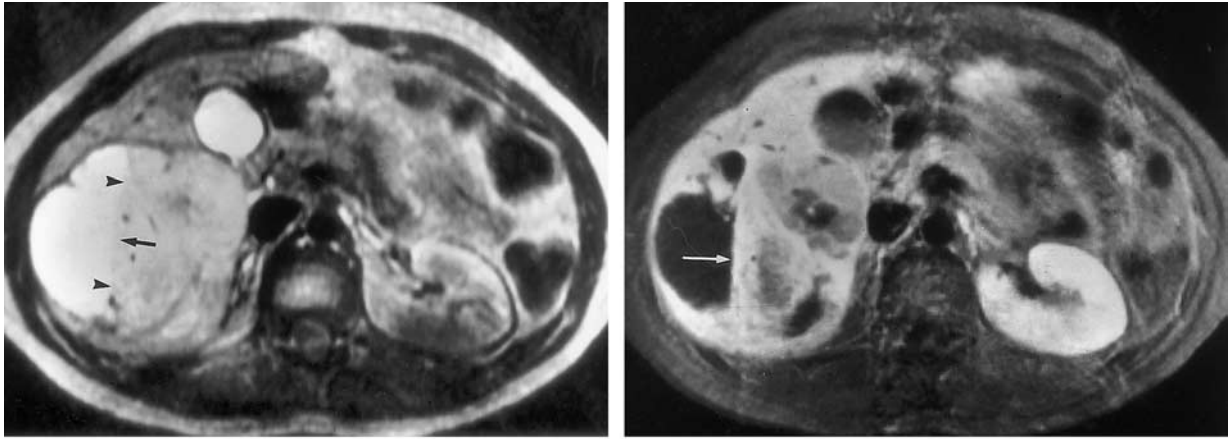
Undifferentiated embryonal sarcoma in a 36-year-old woman. (a) T2-weighted MR image shows a mass in the right lobe of the liver. The solid portions of the mass (arrowheads) are hyperintense relative to normal liver tissue, and the cystic portions (arrow) have signal intensity similar to that of water. (b) Delayed-phase gadolinium-enhanced T1-weighted MR image shows heterogeneous enhancement of the solid portions of the lesion (arrow).
